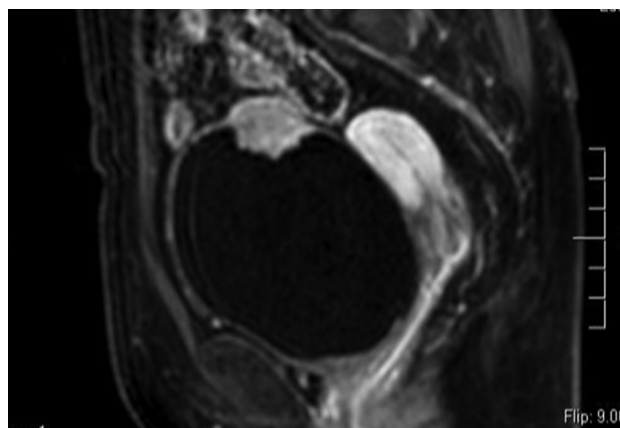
Magnetic resonance imaging of the pelvic cavity with T1-weighted imaging.
